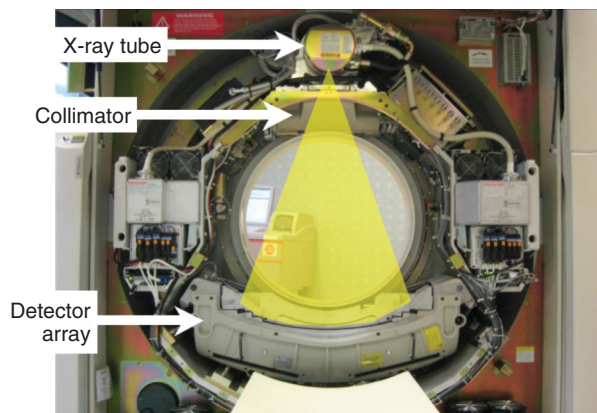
View within the rotating multidetector CT gantry. Key elements include the x-ray tube or source, a collimator to align the x-ray beam, and the detector array, consisting of narrow channels for detection of x-ray photons. The number of detector channels determines the nomenclature (e.g., 64-row multidetector CT). At present, the maximum number of detectors within a commercially available multidetector CT scanner is 320.
